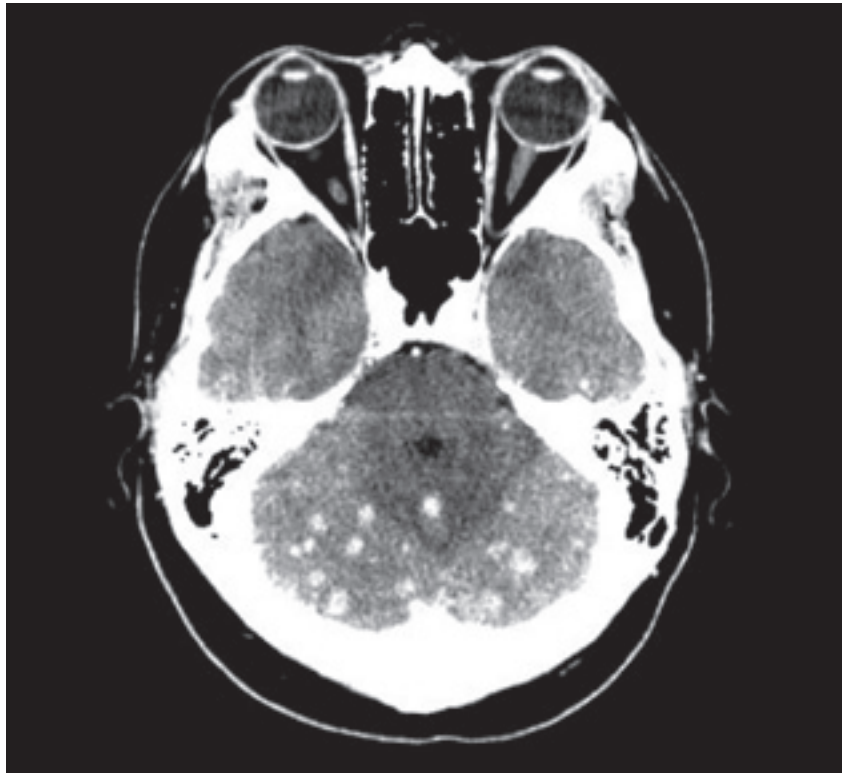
Image from CT head scan with contrast, cerebellar cut, showing diffuse enhancing nodules with cerebellar edema.
